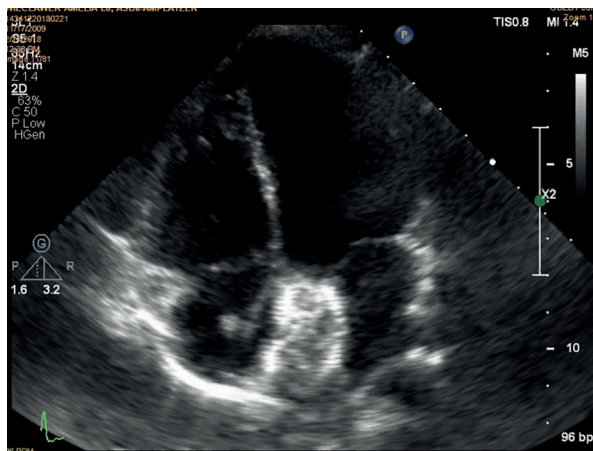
Transthoracic echocardiography 4-chamber view. Correctly positioned implant, No septal leakage. Significant reduction in the size of the chambers of the right heart
